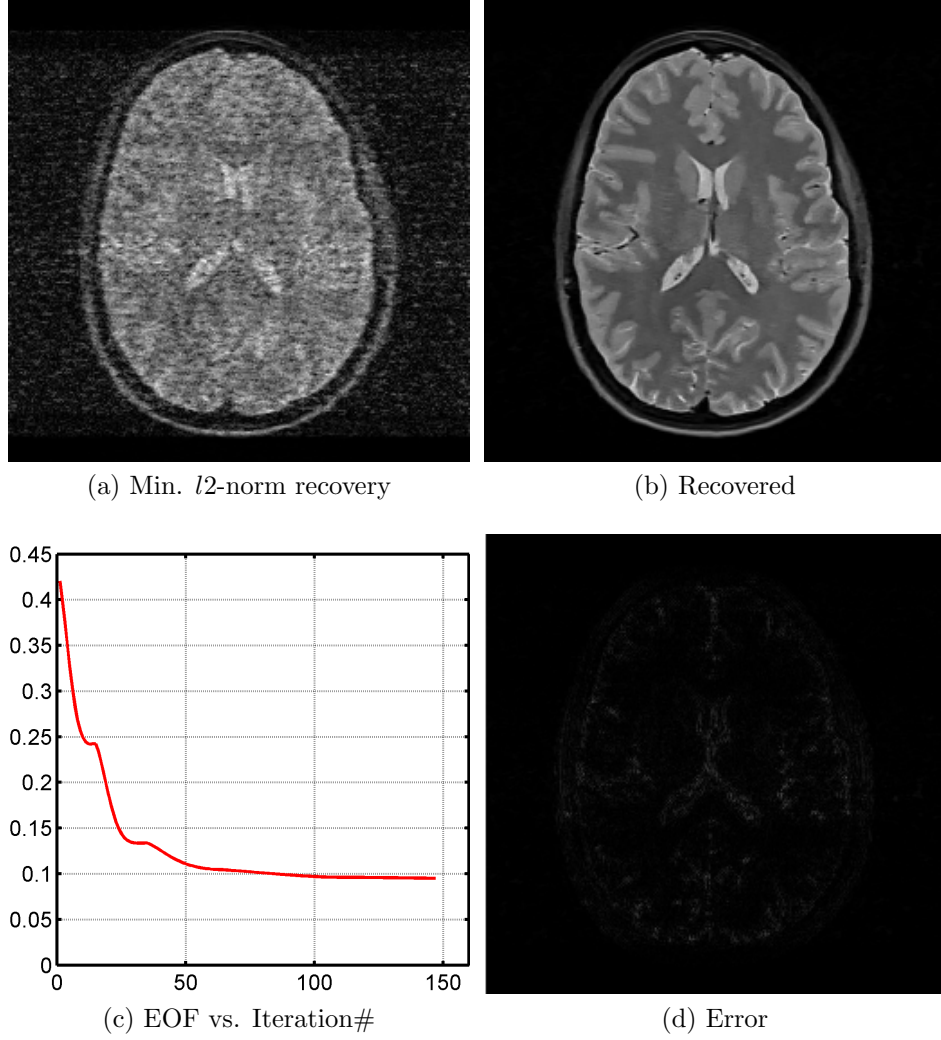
Recovery of a T2-weighted brain image using sparsity of image-patches in a K-SVD trained dictionary and the tagging radio-frequency based signal MR encoding at an acceleration of $R=4$. (a) Minimum energy recovery using acquired TAG samples (b) Final recovered image (c) Relative error vs. iteration curve (d) Magnitude error image
